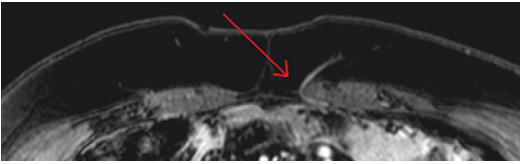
Axial MRA. Arrow points to septocutaneous perforator. (From Greenspun D, Vasile J, Levine JL, et al. Anatomic imaging of abdominal perforator flaps without ionizing radiation: seeing is believing with magnetic resonance imaging angiography. *J Reconstr Microsurg* 2010;26(1):41; with permission.)
